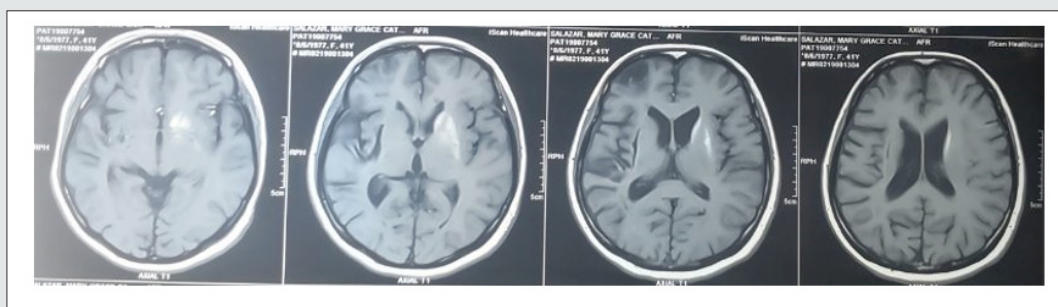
Cranial MRI with contrast T1 sequence.
